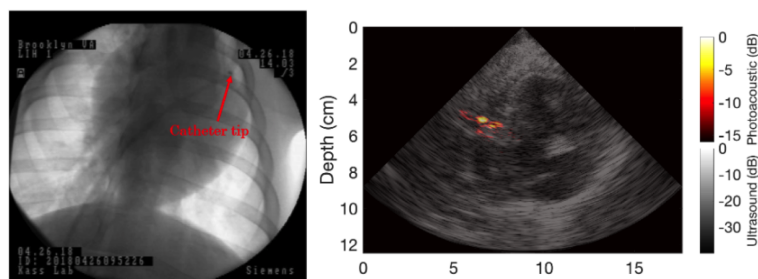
(left) Posterior-anterior fluoroscopic image acquired with the cardiac catheter tip in contact with the right ventricular outflow tract. (right) Corresponding subcostal photoacoustic image overlaid on co-registered ultrasound image.
